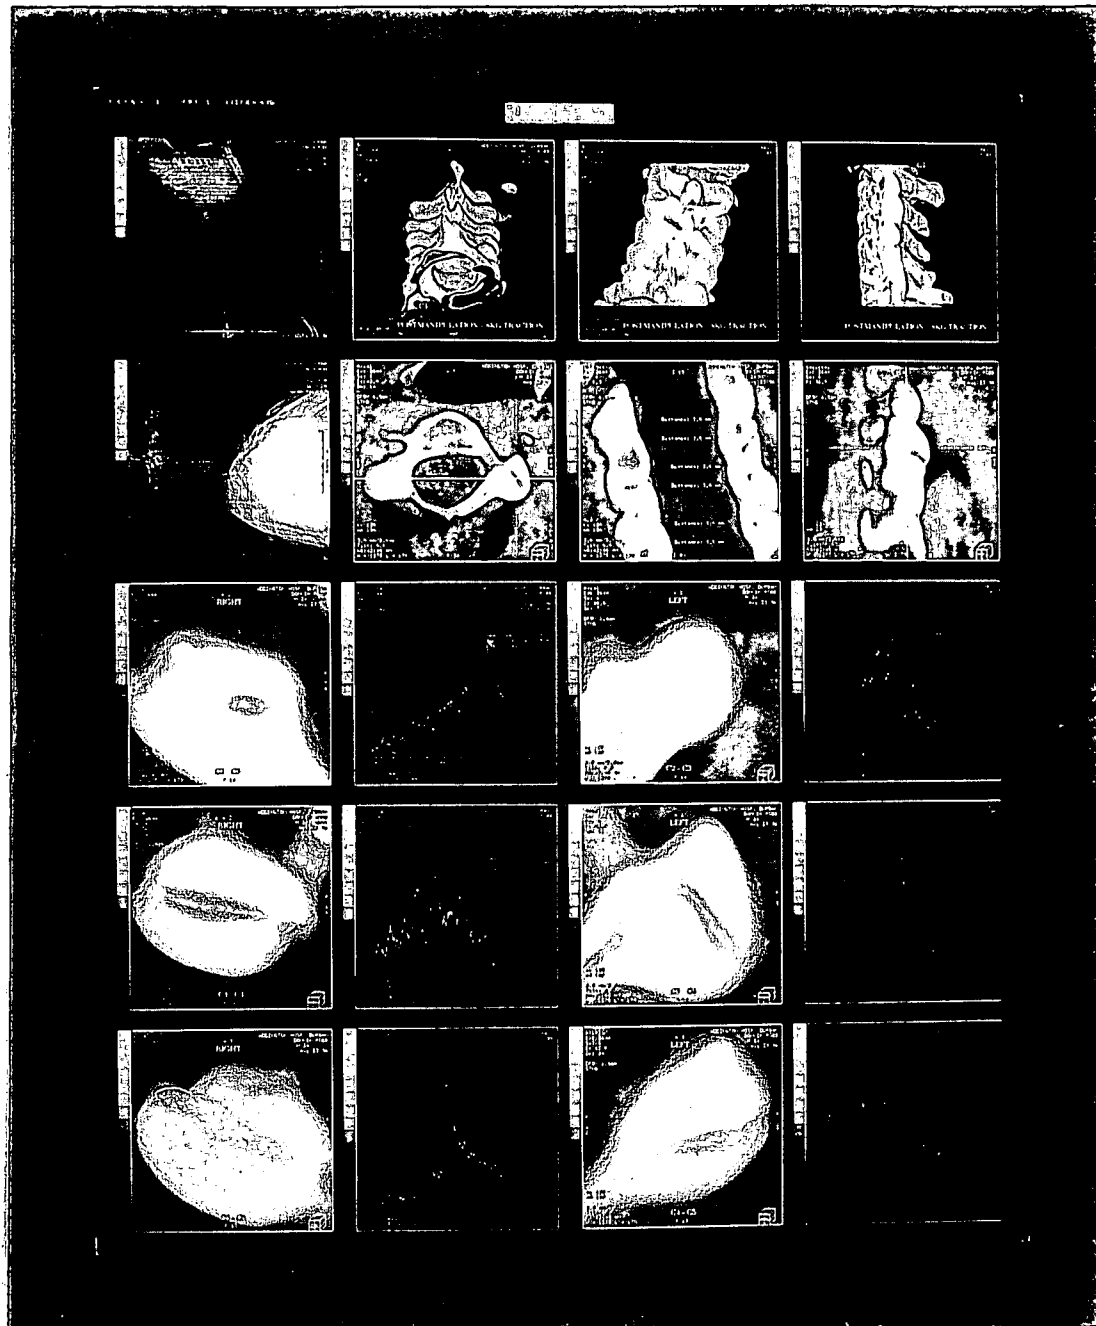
Experiment 5 : Post-manipulation + 8kg traction CT scan
